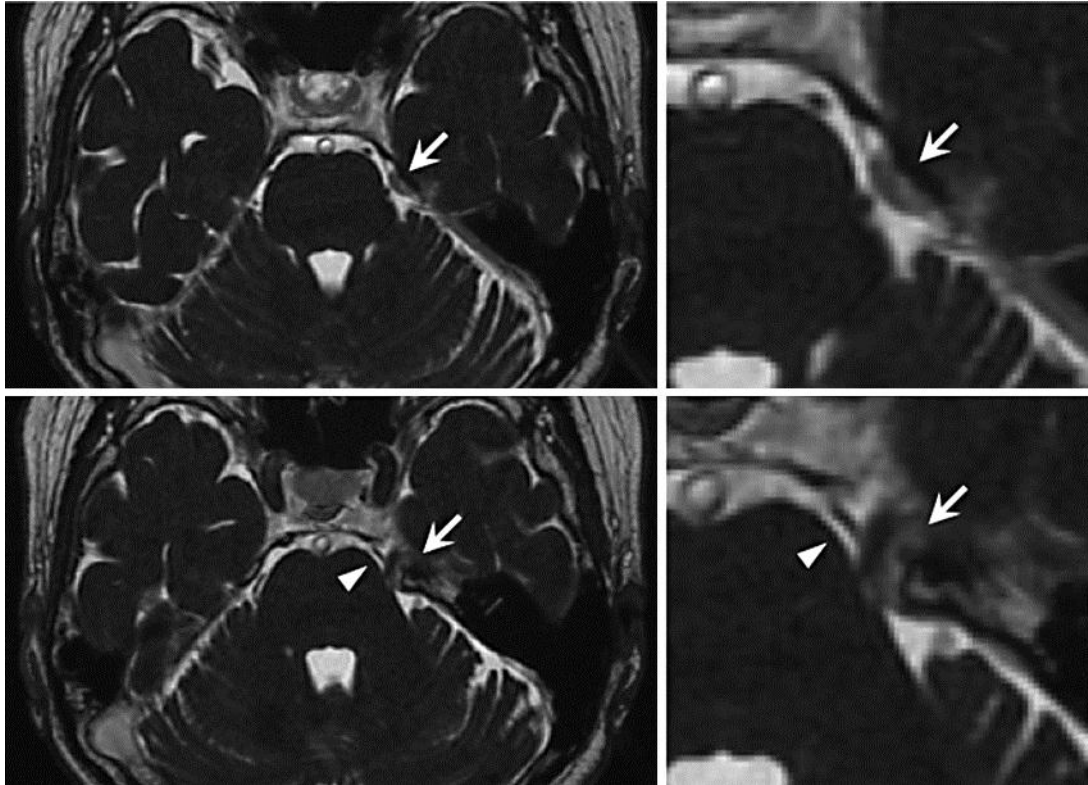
Preoperative 3D FIESTA MR images showing an extra-axial tumor (arrow) at the entrance of Meckel's cave that medially compressed and distorted the trigeminal nerve root. The SCA (arrowhead) runs medially proximal to the trigeminal nerve.
